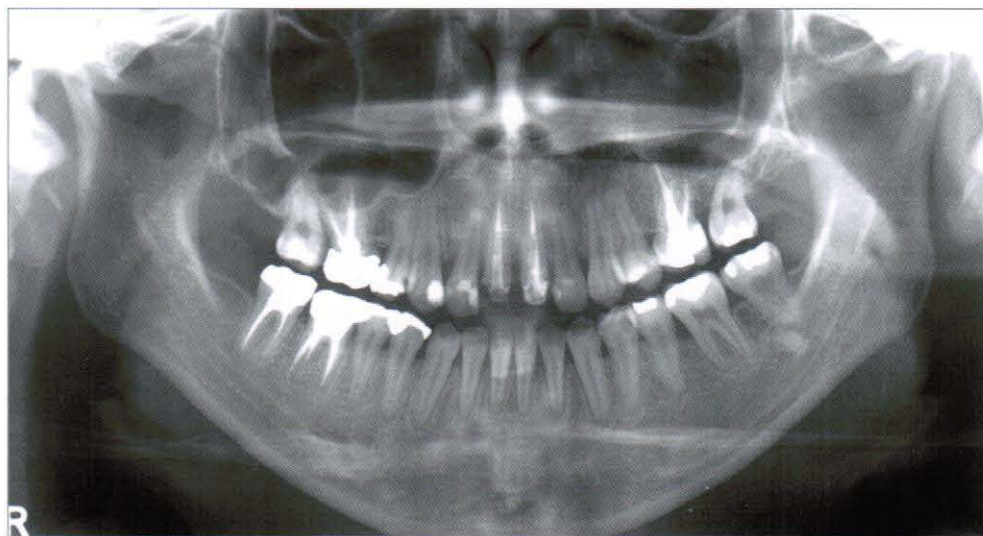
Panoramic radiograph at debonding (2007, 8,17)
